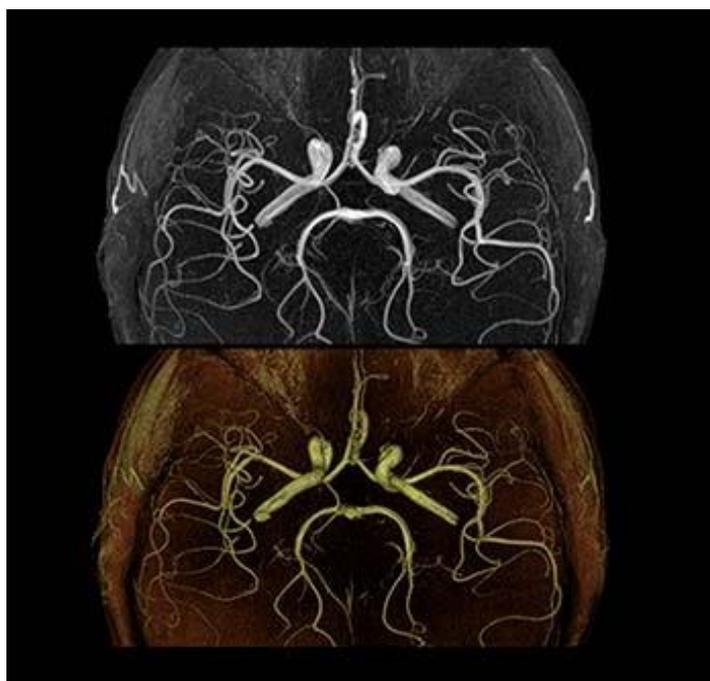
NON CONTRAST MRI ANGIOGRAPHY, TOF (TIME-OF-FLIGHT)
